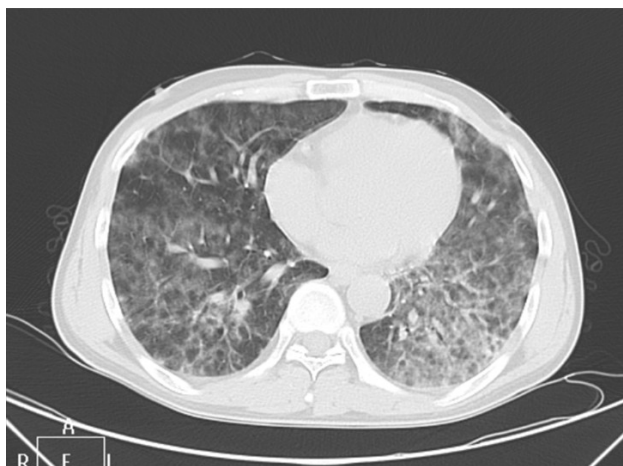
Pulmonary features in transverse CT
